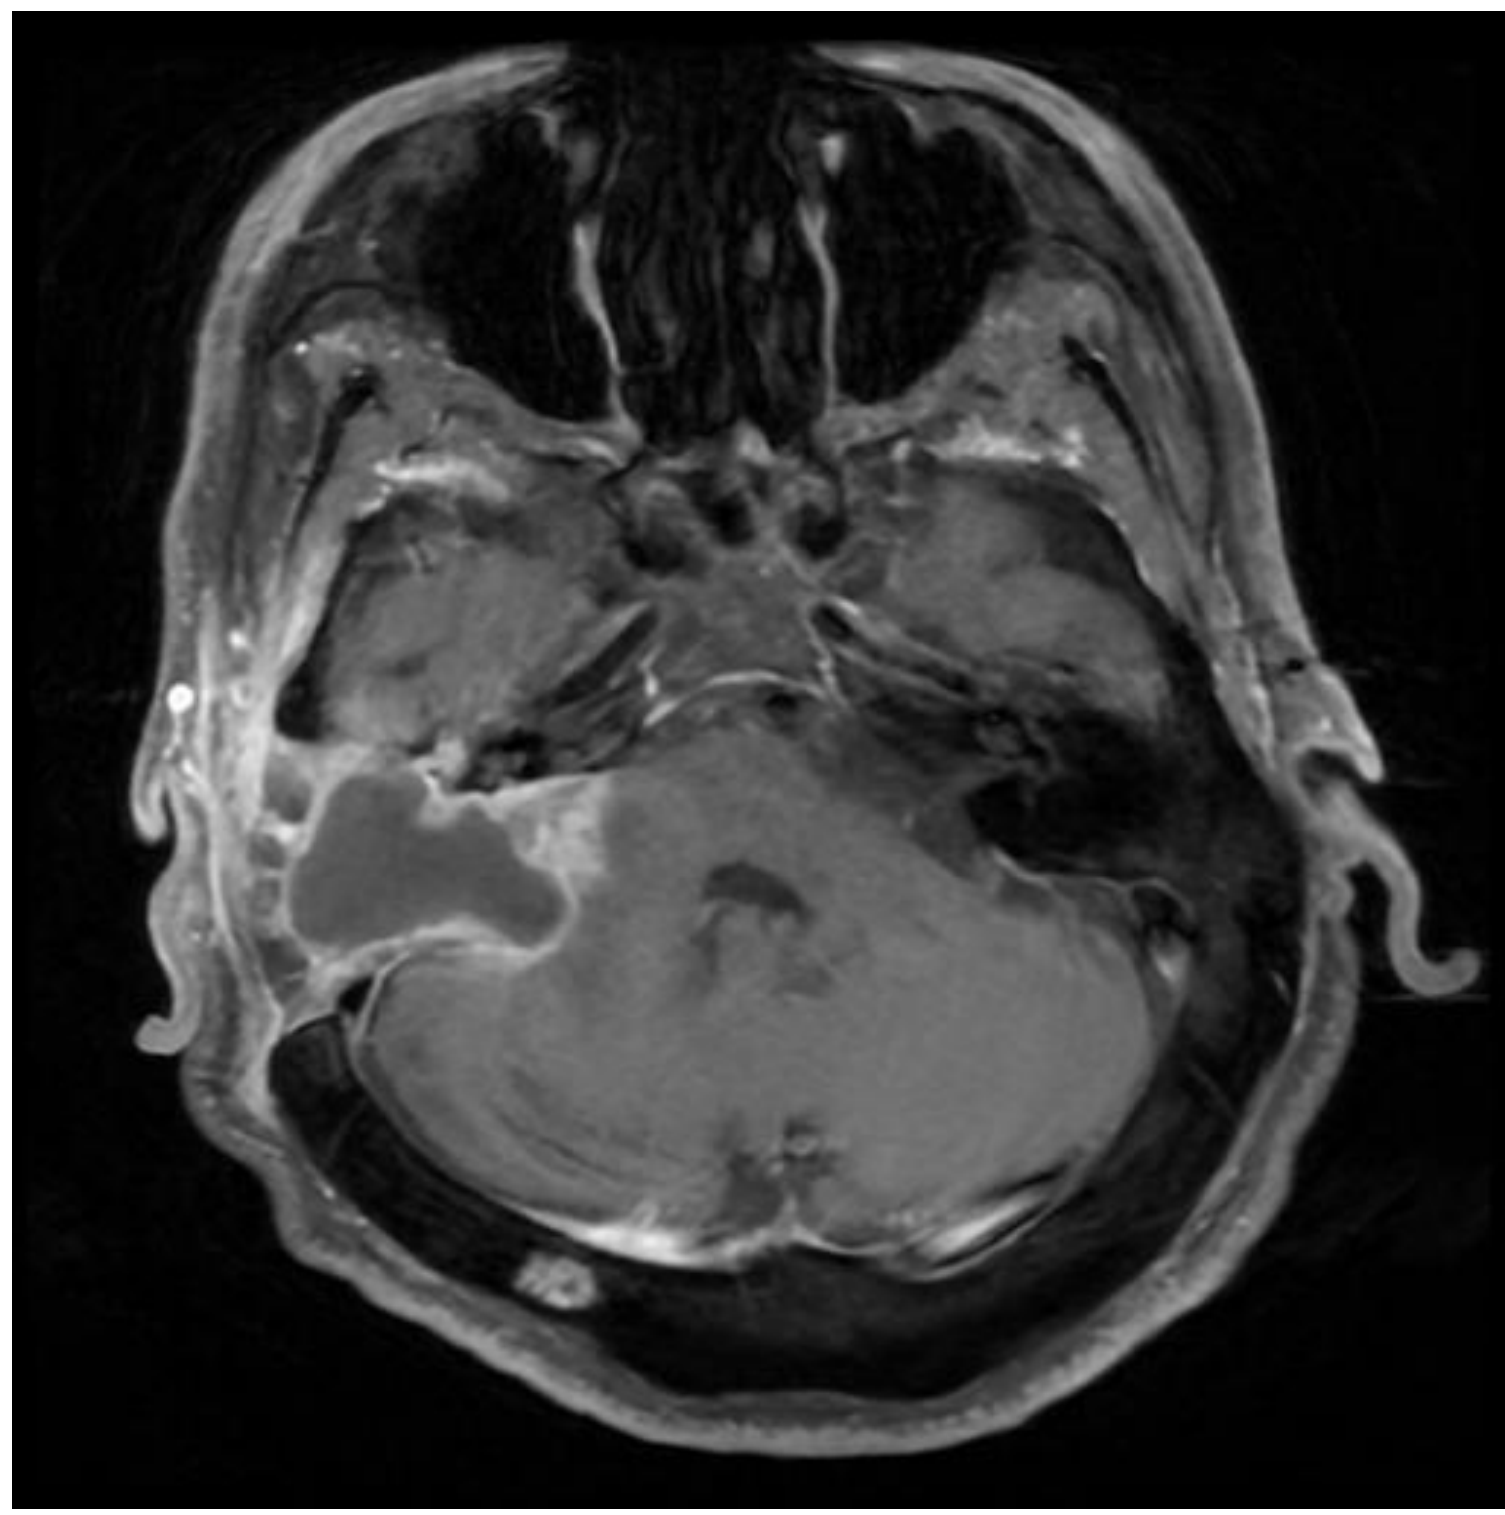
MRI demonstrating complex cystic, enhancing mass in prior resection cavity.
